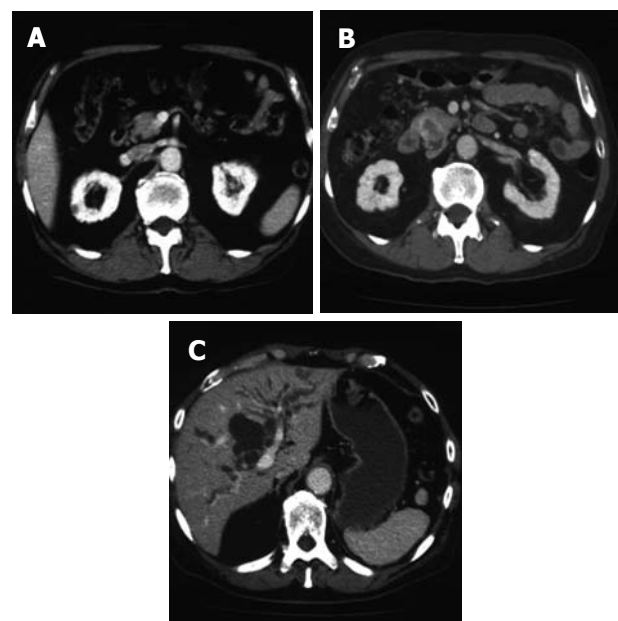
The pancreatic head tumor not detected by preoperative abdominal CT (A), a 25 mm \times 17 mm tumor in the pancreatic head detected by abdominal CT with its periphery enhanced by contrast material in the delayed phase (B) and dilatation of intra- and extra-hepatic bile ducts observed (C).
